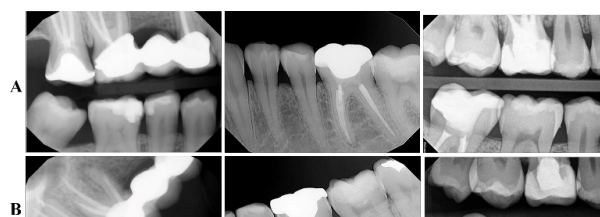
Radiographic image showing the follow up of the multi-layered zirconia endocrown.
